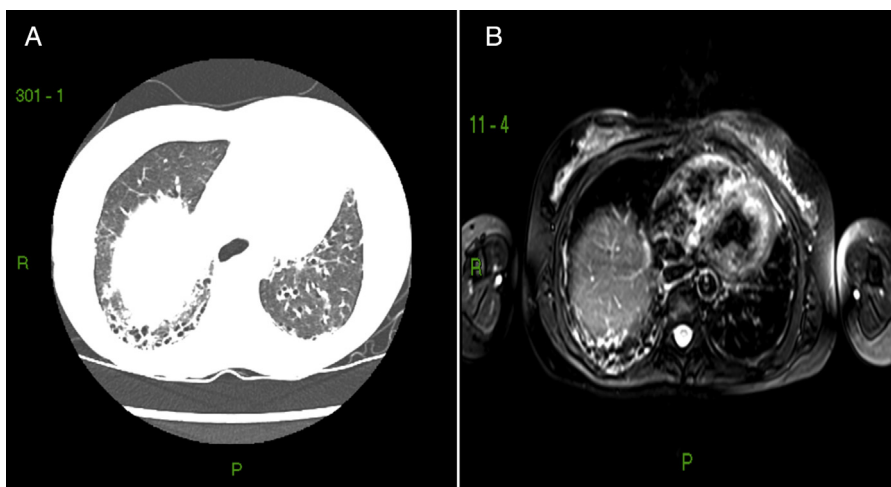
Respectively, chest CT and chest MRI of patient with SSc. A shows an area of reticular infiltrate in the lower lobe of the right lung, with traction bronchiectasis and minimal ground-glass attenuation areas; B, shows an increase in T2 signal in the corresponding area.
